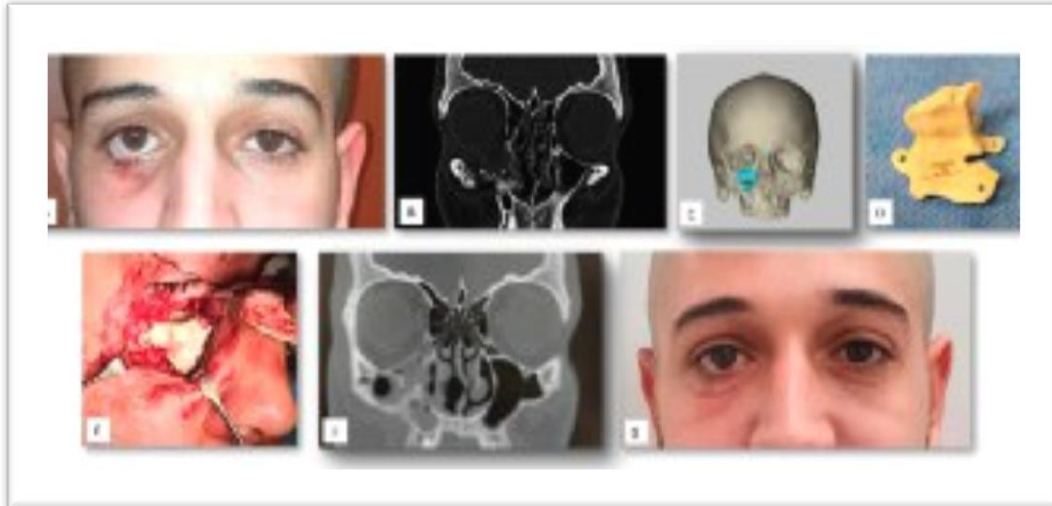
A) A clinical view shows significant right-sided enophthalmos, cicatricial ectropion (B) A preoperative coronal computed tomography (CT) scan shows the defect of the right infraorbital rim (C) Pre-operative 3D planning. (D) Individual custom reconstruction implant. (E) A post-operative coronal CT scan shows the position of the right infraorbital rim. (F) Postoperative implant position. Coronal CT scan shows the position of the right infraorbital rim.(G) Clinical view shows an accepted postoperative esthetic result.
